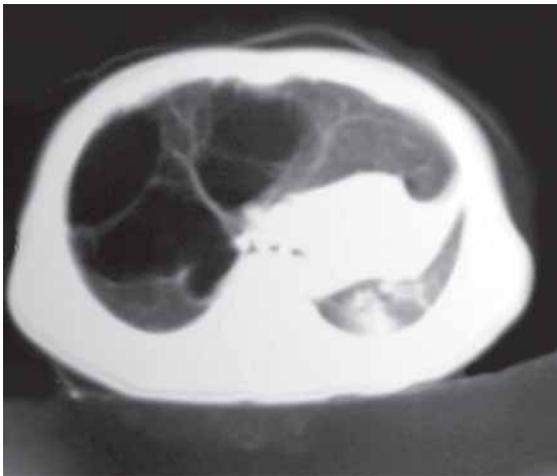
CT appearance in CCAM
